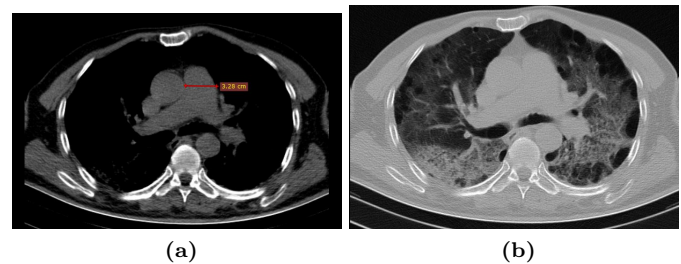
Axial unenhanced CT (a, b) of a 51-year-old female COVID-19 patient's main pulmonary artery diameter, shows bilateral ground glass opacities with superimposed inter and intralobular septal thickening (crazy-paving pattern) with CTSS 21.
